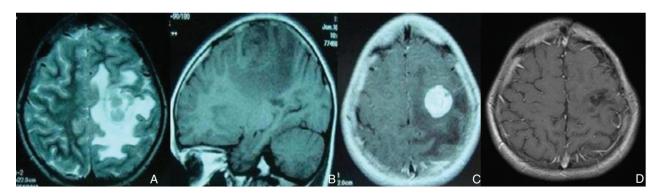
Axial T_2 -weighted (A) and sagittal T_1 -weighted (B) MR images show the left frontal intra-axial mass lesion that was hyperintense on T_2 -(A) and hypointense on T_1 -(B) weighted images. The lesion shows intense and homogeneous enhancement on postcontrast T_1 -weighted (C) image. MR images (A–C) reveal the prominent peritumoral vasogenic edema. T_1 -weighted images show no contrast enhancement was detected in the operation area (D). MR: magnetic resonance.
